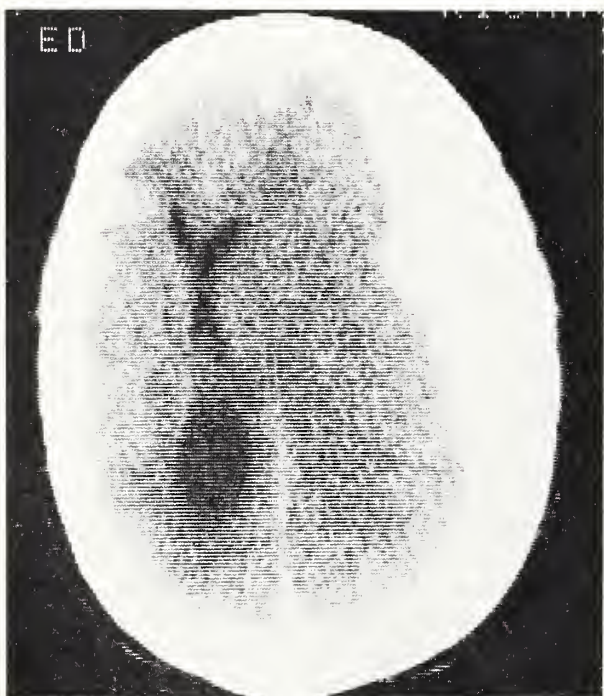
On this CT scan, large right subdural hematoma with 9-mm shift of ventricular system indicates the need for immediate surgical decompression.
